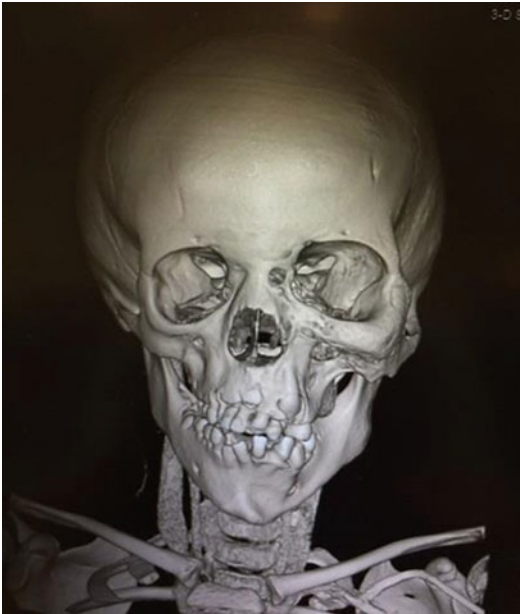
3D reconstructed CT of his face, head, and neck showed hypertrophy of the left maxilla, left zygomatic arch, and left mandible. The left orbital cavity was distorted. There was a predominantly fatty lesion over the left side of his face, enhancing soft tissue and fatty infiltration into the left tongue and the floor of the mouth region. The CT of the neck also showed mild subcutaneous fat hypertrophy over the left side of the neck
